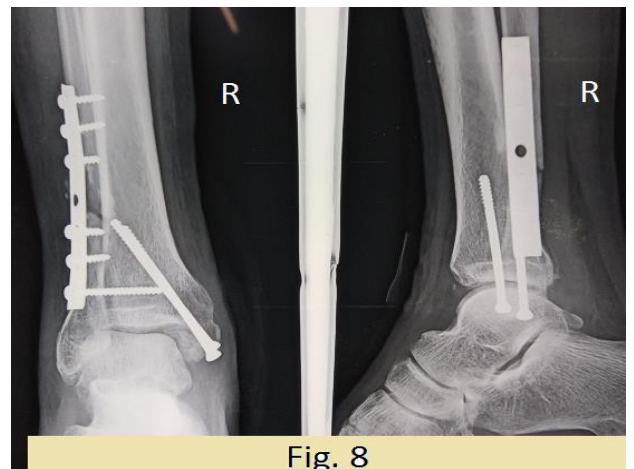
Radiograph of right ankle joint: visualizing bi-malleolar fixation with two AO cannulated screws and fibular fixation by seven holed semitubular plate along with five cortical screws and one syndesmotomic screw.
